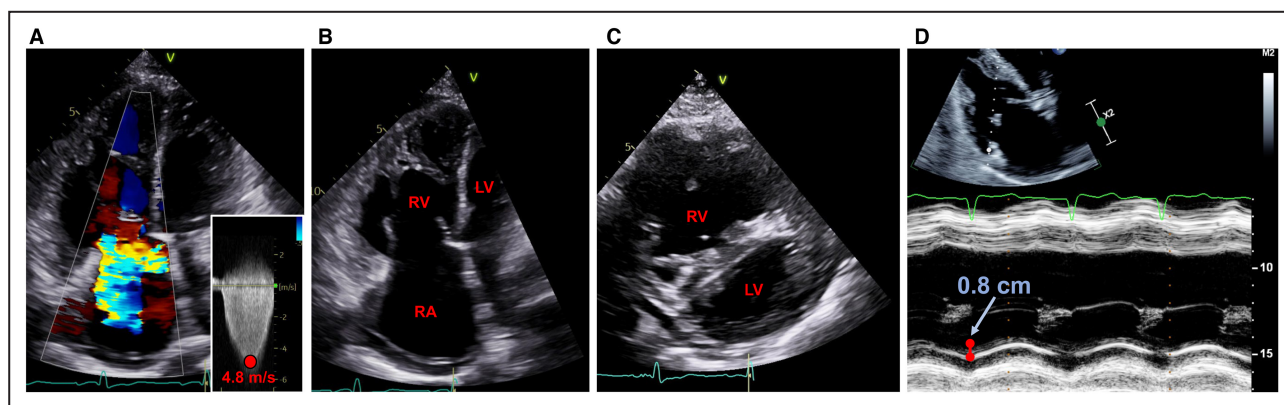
Selected transthoracic echocardiographic findings in pulmonary arterial hypertension (PAH).
